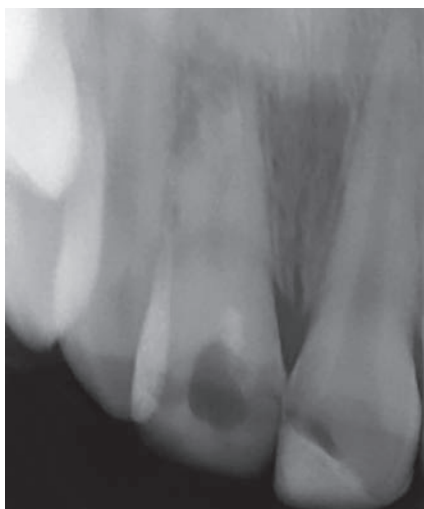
Periapical tooth 11.
